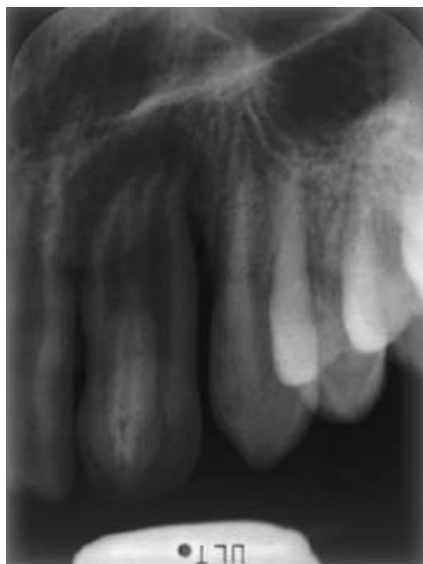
Dental radiograph of the right lateral incisor revealing an invagination extending to the apex and forming a separate foramen.
